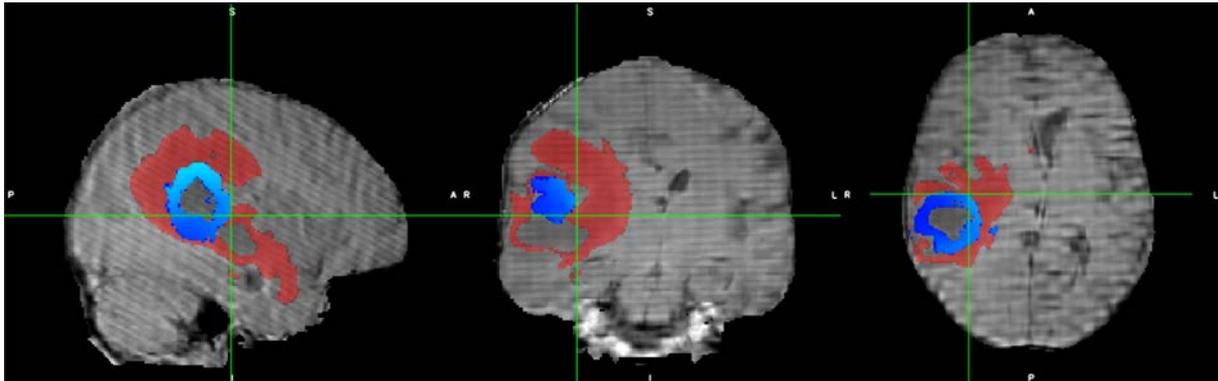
Sagittal, coronal, and axial sections from an artefact-degraded clinical MRI scan: peritumoural oedema and enhancing tumour predictions are shown in red and blue, respectively.
